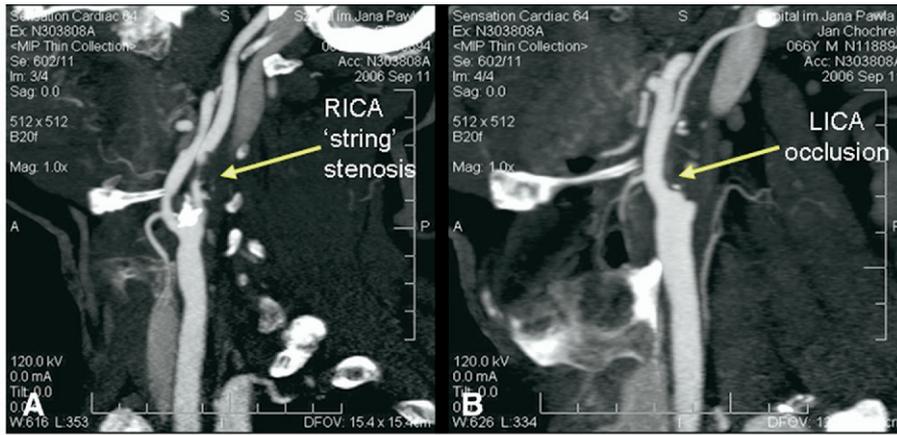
Multislice computed tomography angiography. A, the right ICA string-stenosis; B, occlusion of the left ICA. Doppler ultrasound. C, occlusion of the left ICA; D, the right ICA string-stenosis. Transcranial color-coded Doppler of the Willis circle. E, yellow arrow shows patent posterior communicating artery (PCoA) situated between the right middle cerebral artery (RMCA) and the right posterior cerebral artery (RPCA); F, spectrum registered in the PCoA indicates blood flow from the RPCA to the RMCA.
